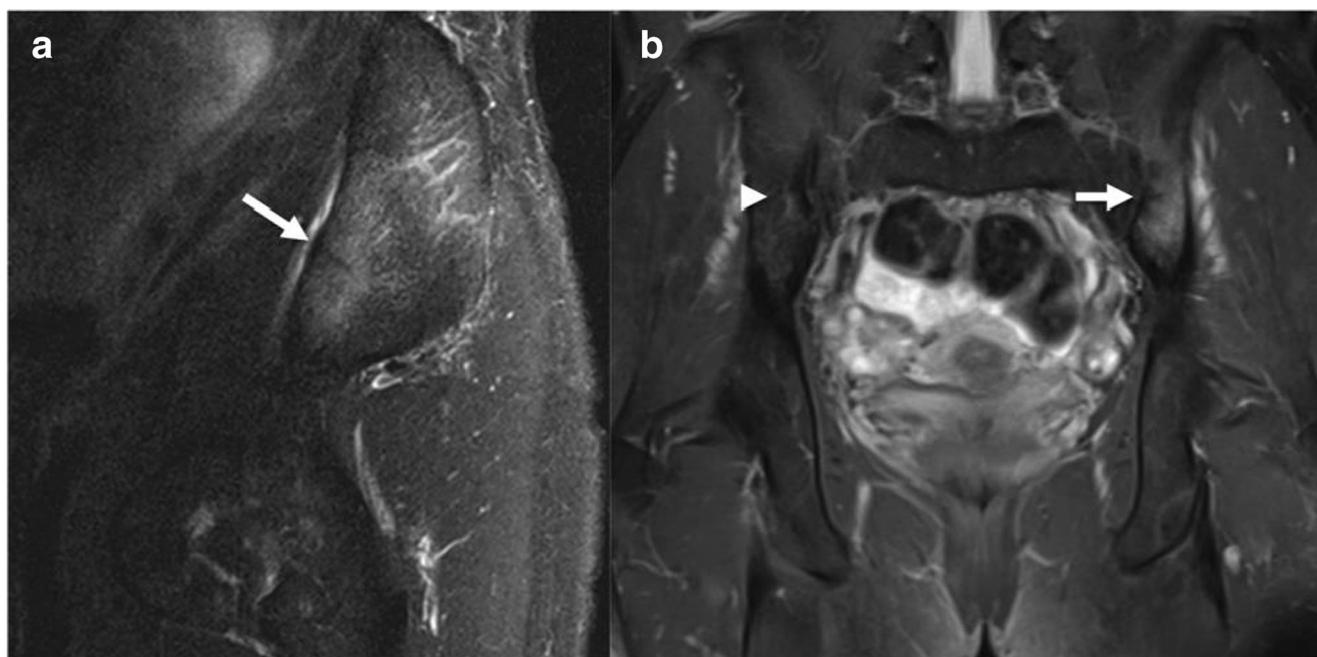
Case #1 MRI. a Sagittal T2-weighted fat-suppressed sequence through the medial aspect of the left iliac bone demonstrates an incomplete, low-signal fracture line (*arrow*), with regional bone marrow edema. b Coronal proton-density fat-suppressed (fluid-sensitive) image through
